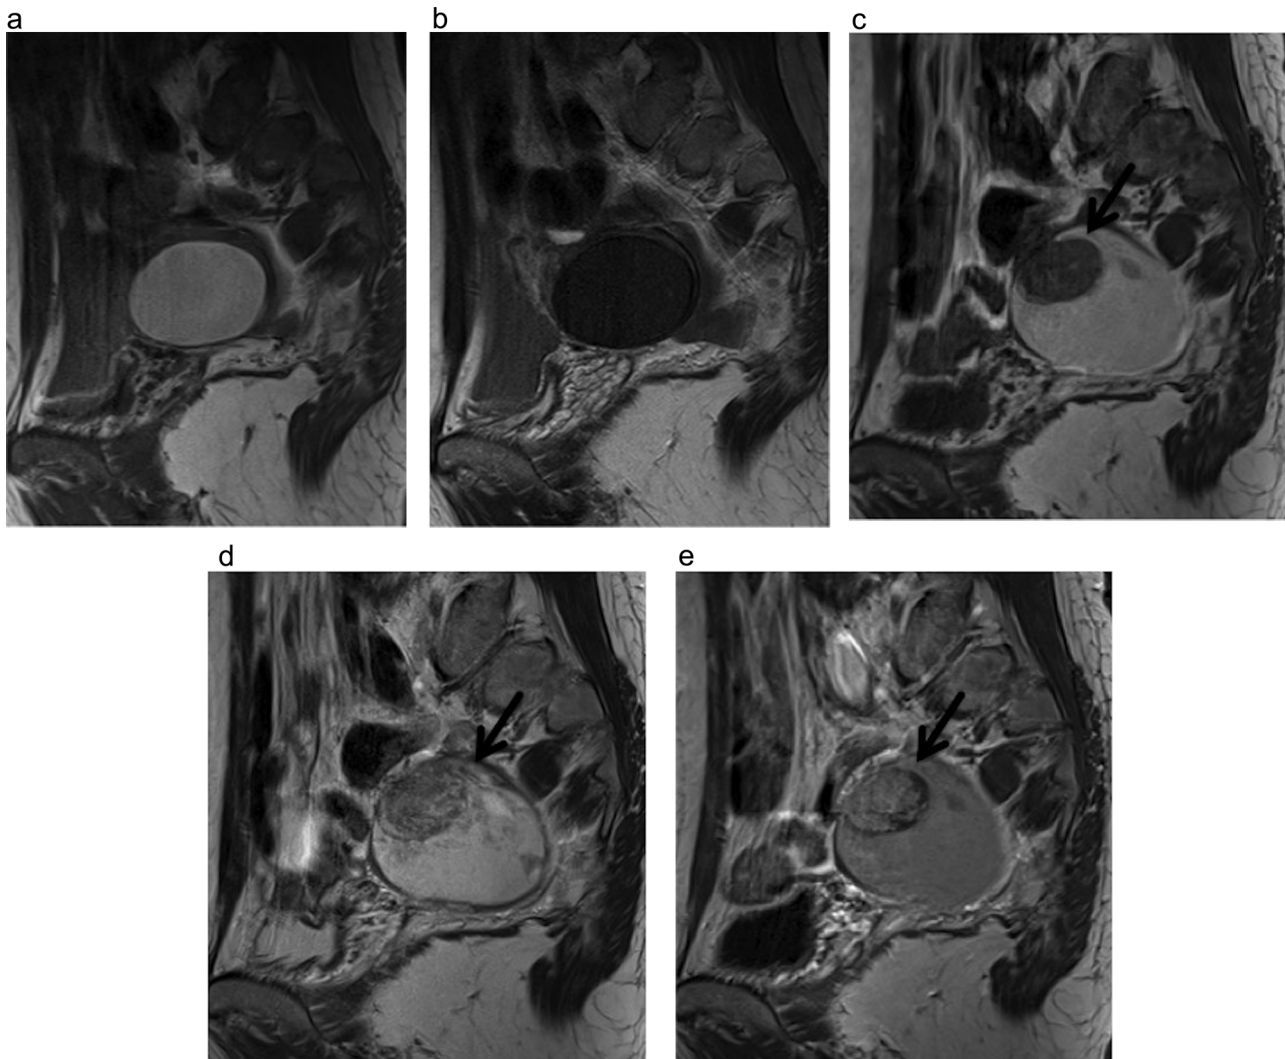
Longitudinal Change from Endometriotic Cyst to Clear Cell Carcinoma Associated with Endometriotic Cyst of the Left Ovary in a 47-year-old Woman (Case 5, on Tables 1 and 2). A–B. Cystic lesion in the left ovary showed high signal intensity (SI) on T1-weighted image (WI) (A), low SI on T2WI with shading (B). No mural nodule was identified and diagnosed as endometriotic cyst. C–E. T1WI (C), T2WI (D), Post-contrast T1WI (E) of the same woman after 4.5 years. The tumor was enlarged from 54 to 65 mm at largest diameter. Nodular portion on the anterior wall was enhanced after the administration of contrast agent (arrow).
